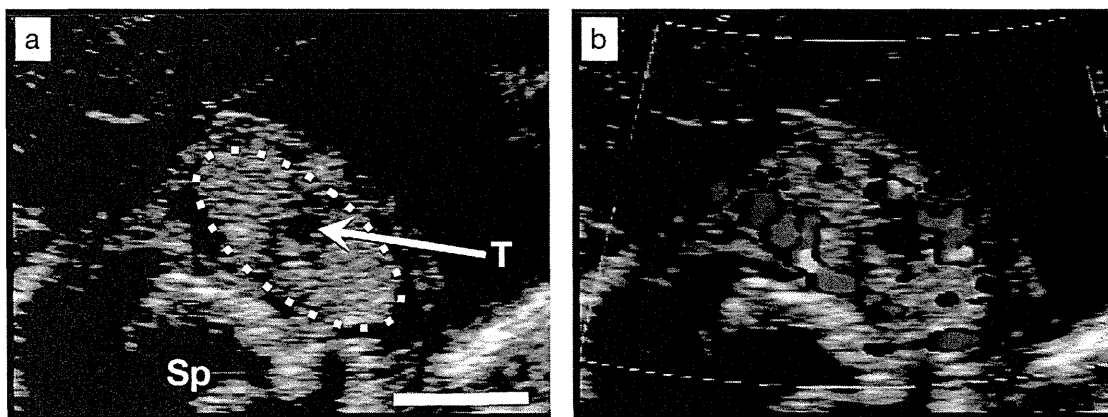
Sonographic features of a fetal goiter
